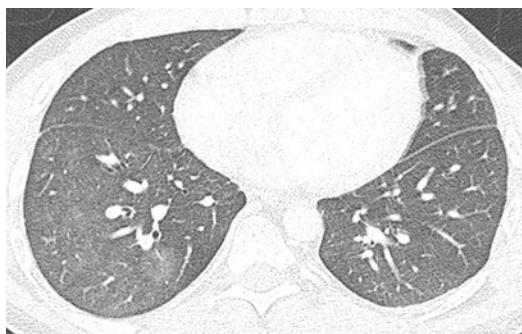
Pneumonia on CTPA in a 43-year-old man with fever and dyspnea. Axial image from a CTPA with lung window demonstrates subtle ground-glass opacity in the right lower lobe. This is an early pneumonia that was not visible on the chest radiograph obtained earlier the same day (not shown)
